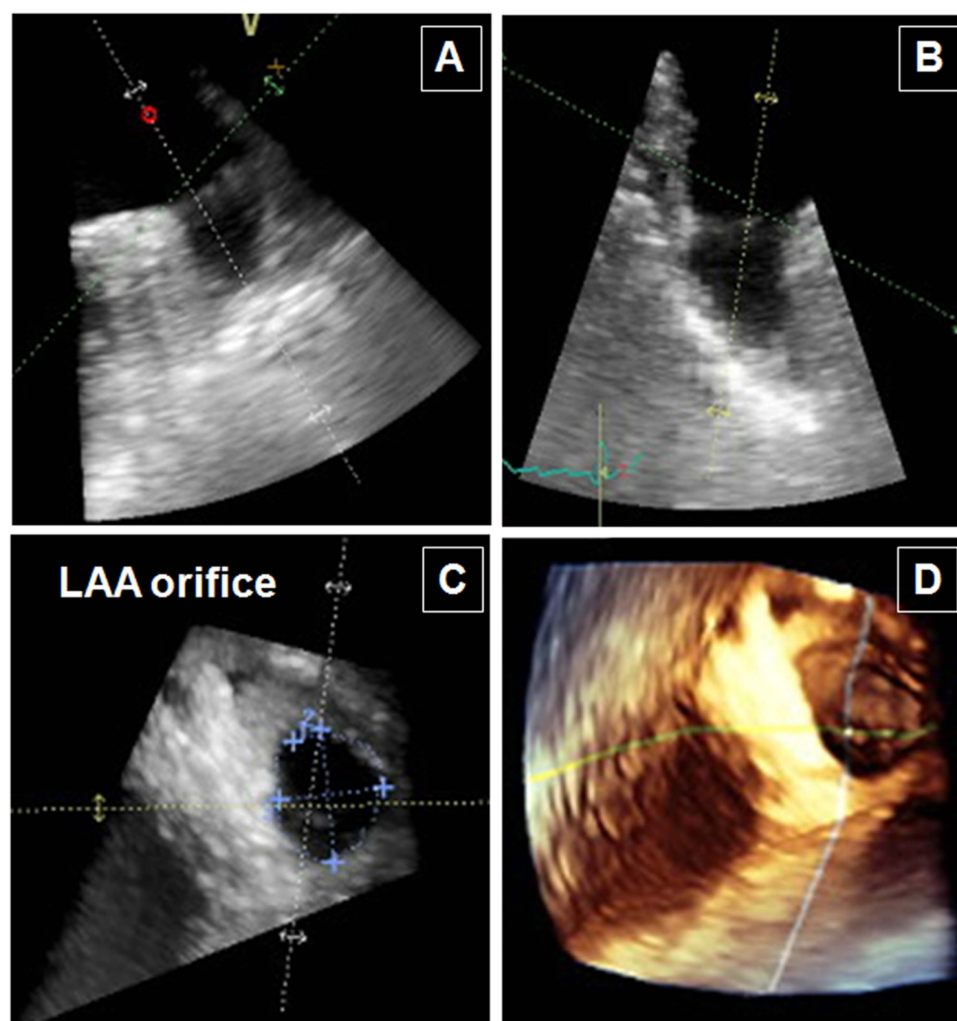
(A, B) Left atrial appendage (LAA) obtained using 3D transoesophageal echocardiography. The LAA long axes were aligned allowing visualisation of the LAA orifice in the short axis and the landing area where the measurements of the LAA should be performed to select the Amplatzer Cardiac Plug device size. (C) The area of the LAA orifice, as well as the maximum and minimum diameters of the LAA, can be obtained. (D) 3D reconstruction of the LAA orifice.
